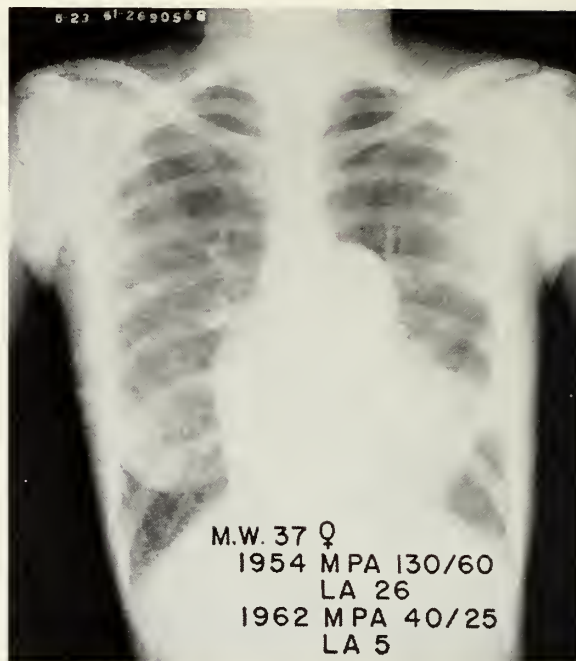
This x-ray was taken eight years following a successful mitral valvotomy. The patient was asymptomatic and had normal cardiodynamics at the time of cardiac catheterization in 1962.
